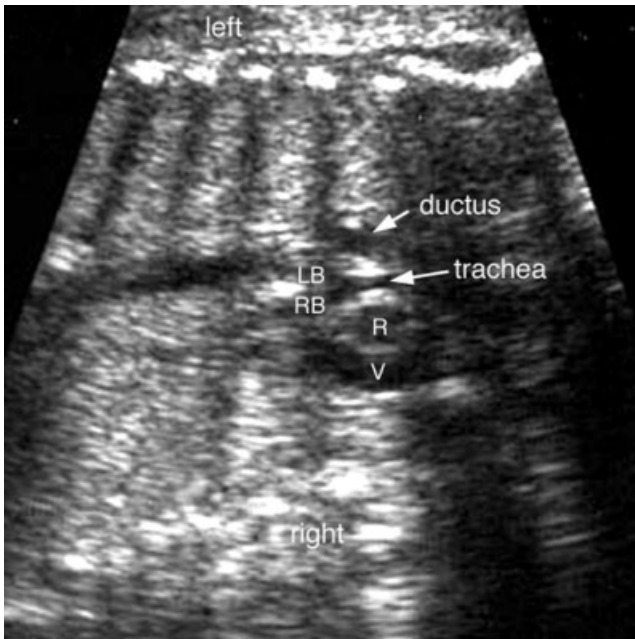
Right aortic arch with aberrant left subclavian artery. Coronal sonogram of the chest shows the aortic arch (R) on the right side of the trachea and the ductal arch on the left side. It is not distinguishable from the coronal view of the double aortic arch as shown in Figure 15. LB, left main bronchus; RB, right main bronchus; V, superior vena cava.
